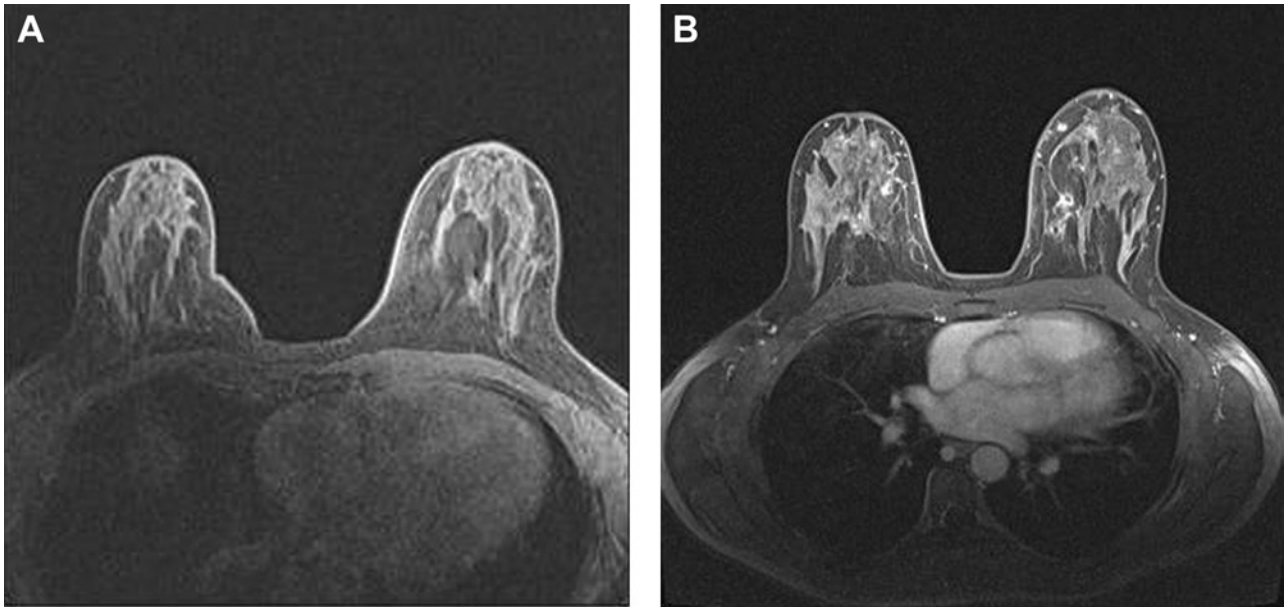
(A) Preoperative and (B) postoperative magnetic resonance images showing volume measurements of fat extrapolated from pixels. Note the difficulty in assessing the breast parenchyma without including the sternum or lateral chest wall.
